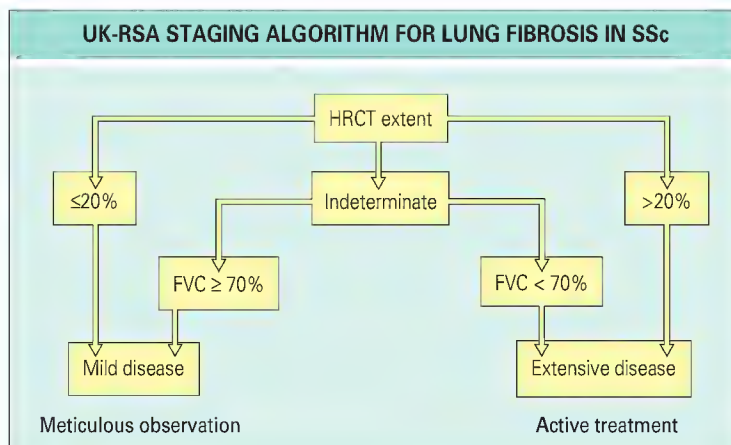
This simple staging system for lung fibrosis in systemic sclerosis (SSc) is derived from analysis of data for a cohort of well-characterized SSc cases and links results of lung function tests and high-resolution computed tomography (HRCT) that are routinely used in disease assessment. Cases can be separated into mild or extensive, and patients with the former may be observed without treatment because they have a lower risk of future progression. Documented worsening should prompt initiation of therapy, currently with immunosuppressive drugs as outlined in the text. FVC, forced vital capacity. (From Goh NS, Desai SR, Veeraraghavan S, et al. *Interstitial lung disease in systemic sclerosis: a simple staging system*. *Am J Respir Crit Care Med* 2008;177:1248-54.)
